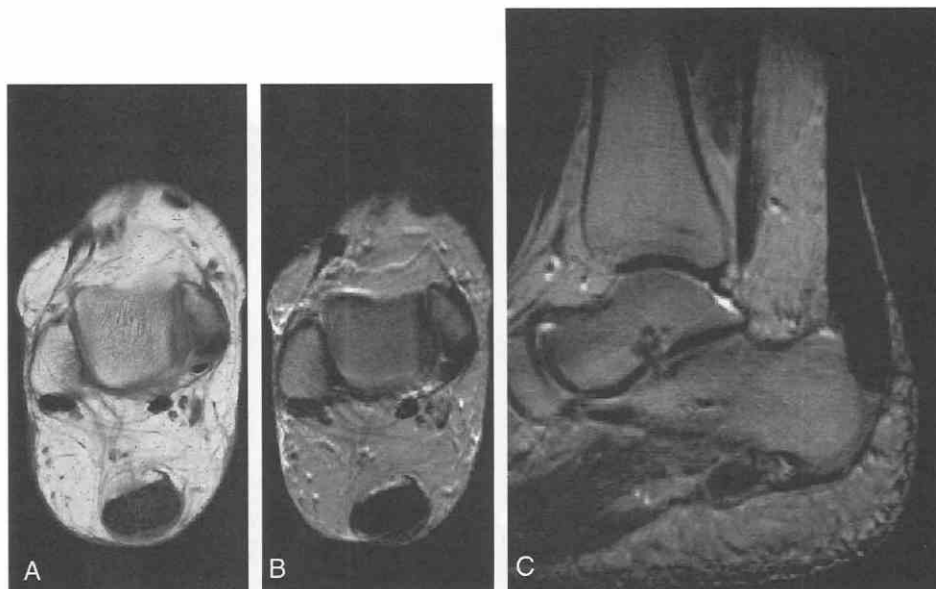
The patient is a 57-year-old woman with an Achilles tendon that has healed with chronic scarring. Axial T1-weighted (A), axial T2-weighted (B), and sagittal T2-weighted (C) images reveal that the distal Achilles is too round and thick but contains no increased signal.
